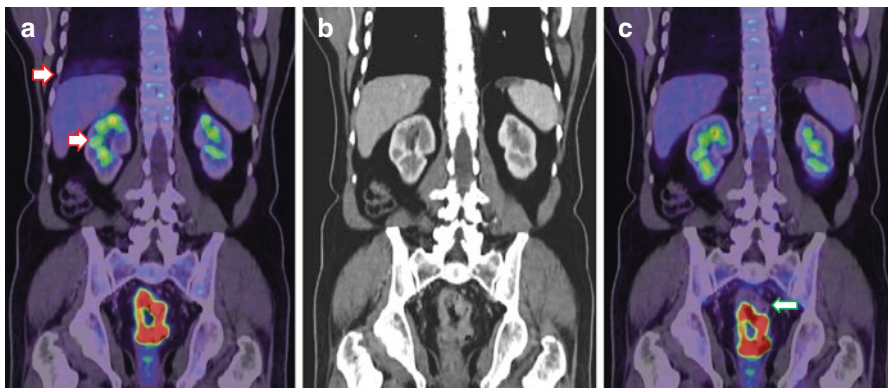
Misregistration of liver and renal FDG uptake (a - coronal fused PET/CT, b - coronal contrast enhanced CT) due to respiratory movement (red arrows). (c) Images after manual correction for misregistration of liver and renal activity, but it induces misregistration at the site of pathological FDG uptake in the lesion in the rectum (green arrow). Care should be taken while interpreting images with misregistration
